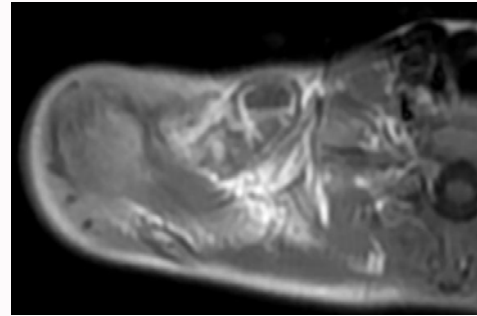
After IV Gd injections, enhancement is observed at the periphery of the lesion on T1-weighted axial image.
